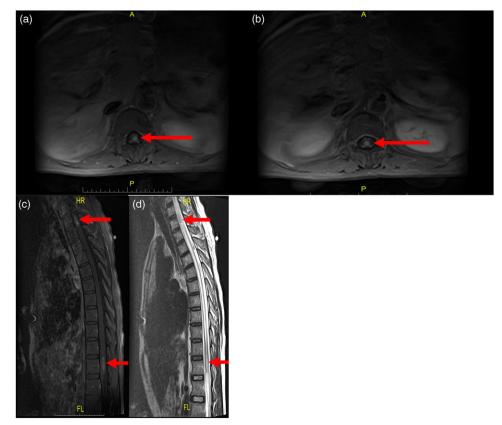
(A–D) MRI of thoracic spine (with contrast, axial sagittal T1 and T2 weighted images) showing an enhancing mass within the spinal canal at T2/T3 (as in 1C–D), intramedullary location, 1.5×0.6 cm, and the second enhancing mass seen distally at the level of T12 involving conus, intramedullary, 2-4 \times 0.7 cm (as in 1A–B), central canal is dilated.
